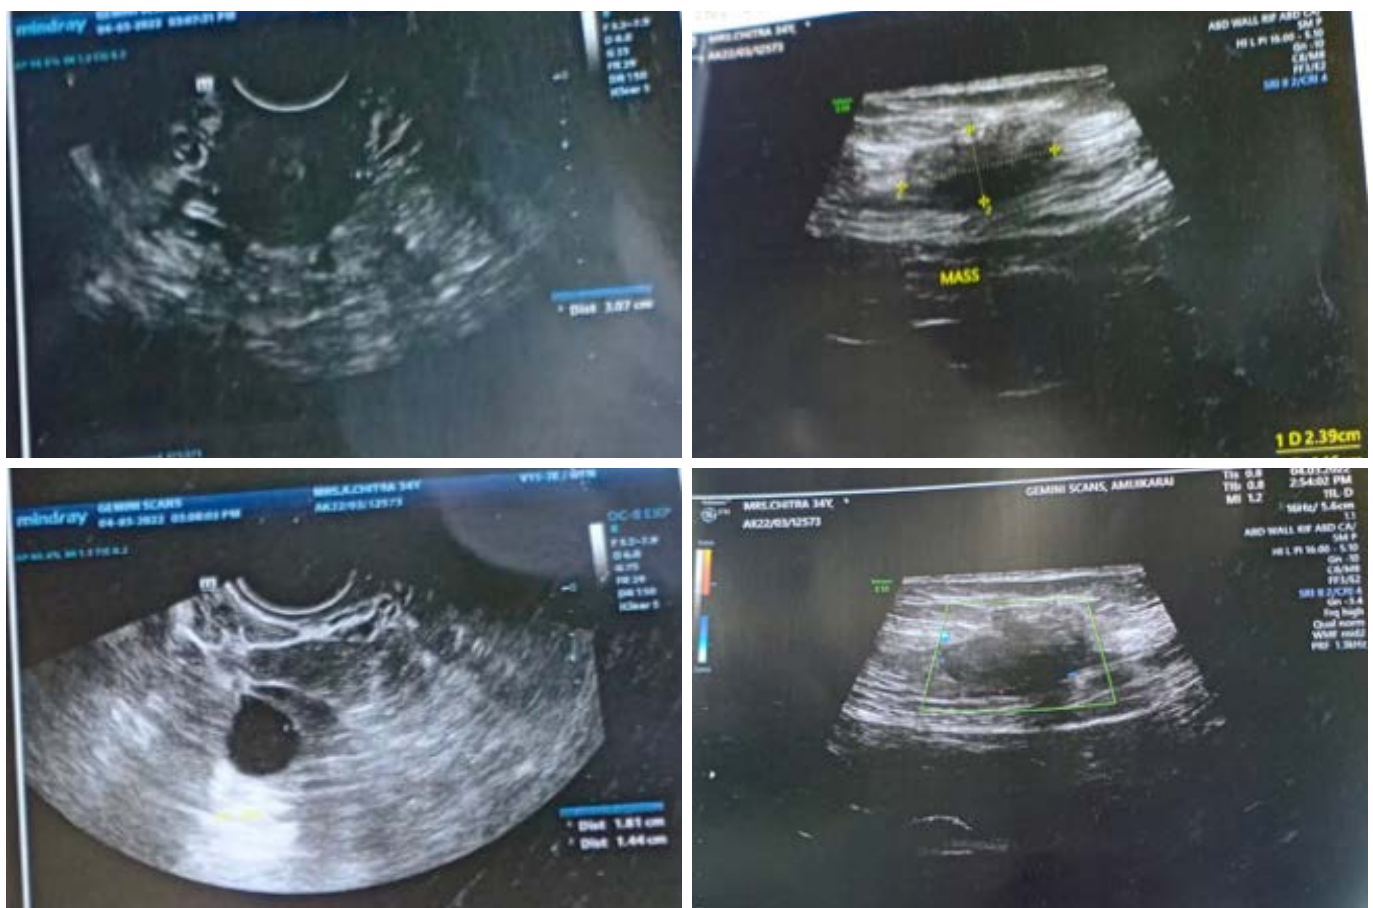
Ultrasound images showing the mass of a scar endometriosis.
